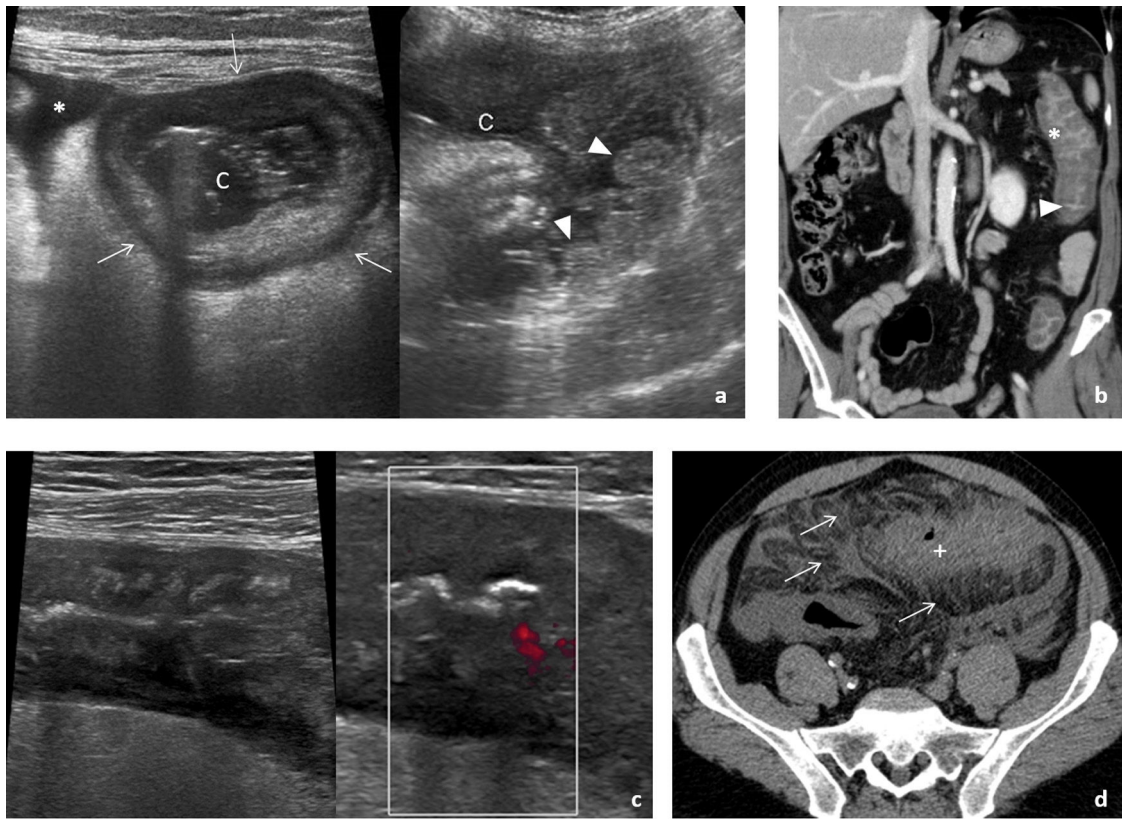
Infectious diseases of the colon. A and B) Pseudomembranous colitis. A) Ultrasound images in a patient with bloody diarrhoea showing a colon (c) with marked wall thickening (arrows) and prominent and irregular internal mucosal folds (arrowheads). There is mild ascites (*). B) Coronal reconstruction from a computed tomography (CT) study in another patient with the same diagnosis, where we can see significant thickening of the wall of the left colon, with a predominance of oedema in the submucosal layer (*) and enhancement of the mucosa (arrowhead), with minimal involvement of the adjacent mesentery, characteristic in this disease. C and D) Ischaemic colitis. Ultrasound images (C) showing the abnormally thickened wall of the left colon with loss of normal stratification. In the Doppler study, it was not possible to detect the presence of flow inside despite using colour Power or Power Doppler, which is much more sensitive to the detection of slow flow. In the axial image of the CT scan (D), performed without contrast due to deterioration in the patient's renal function, we see the thickening of the wall of the sigmoid colon (+), which is accompanied by significant mesenteric fat stranding (thin arrows), findings which usually appear in the reperfusion phase after occlusive or non-occlusive mesenteric ischaemia. Fig. 4 a courtesy of Dr T. Ripollés (Valencia, Spain).
